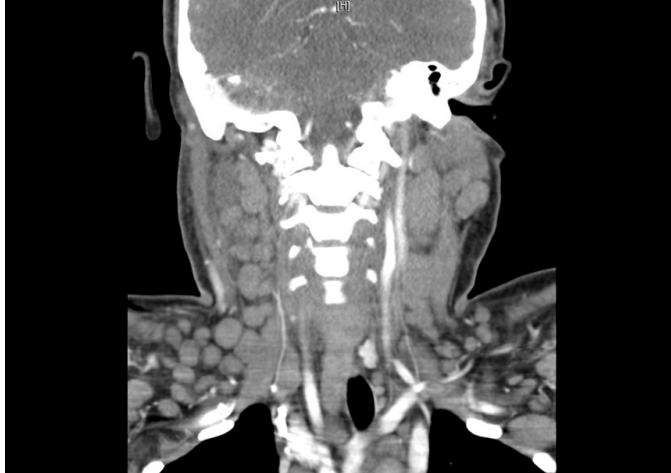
Coronal CT scan of the neck shows extensive generalized lymphadenopathy.
